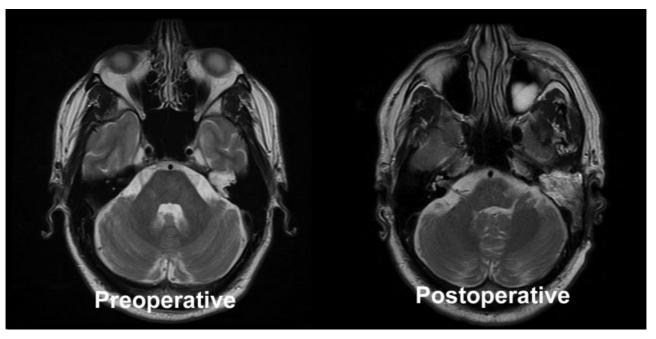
Preoperative and postoperative axial T2 magnetic resonance imaging sequences showing complete resection of a left temporal bone and cerebellopontine angle epidermoid tumor.
